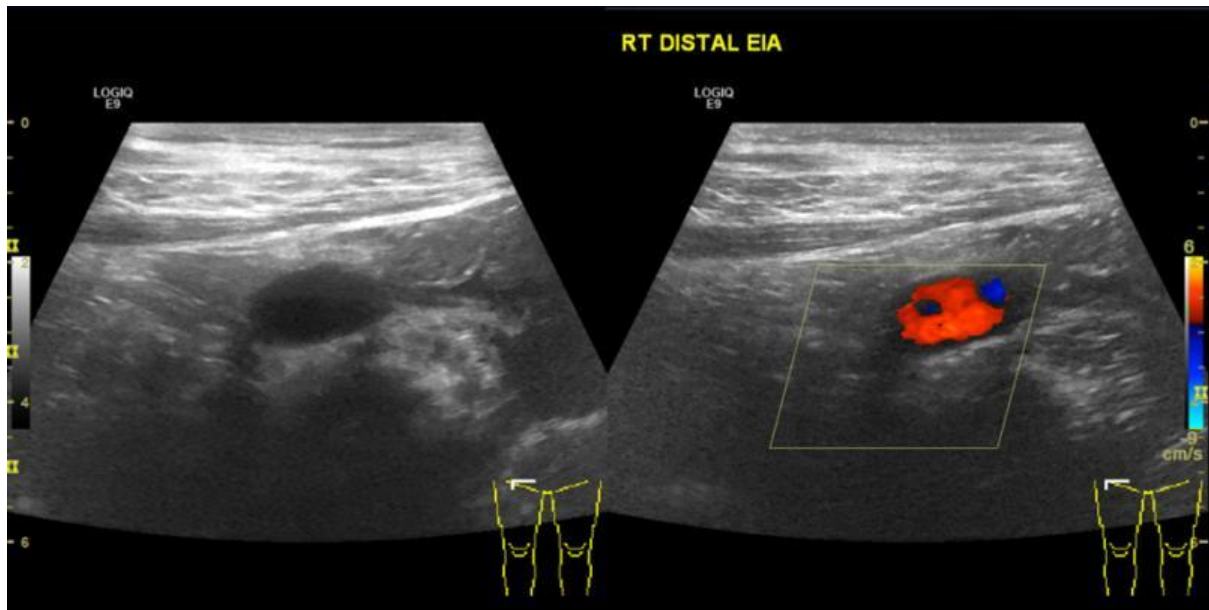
Follow up ultrasound of the right inguinal region shows resolved wall thickening of the right external iliac artery.
